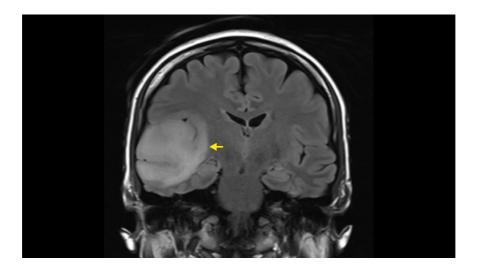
MRI scan of a patient [184]
